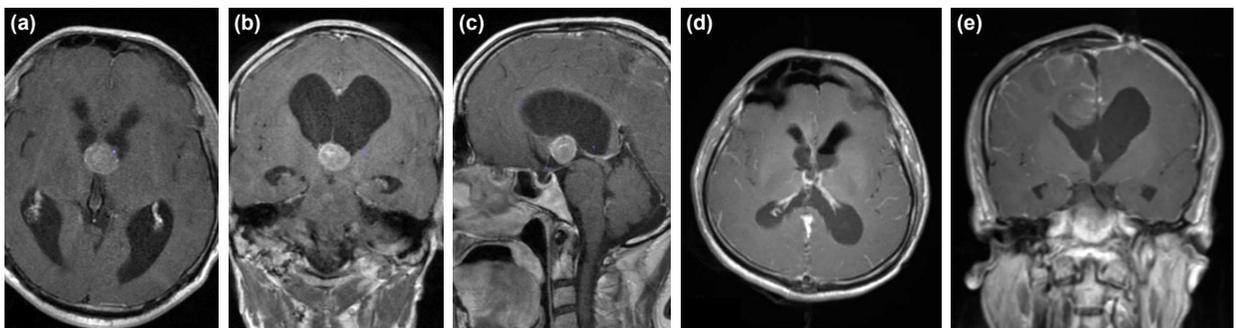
Preoperative contrast-enhanced MRI of a patient from case series revealed a colloid cyst of 3rd ventricle (axial (a); coronal (b); and sagittal (c) T1-WI). Postoperative contrast enhanced MRI of the same patient revealed total resection of the colloid cyst (axial (d); and coronal (e) T1-WI).
